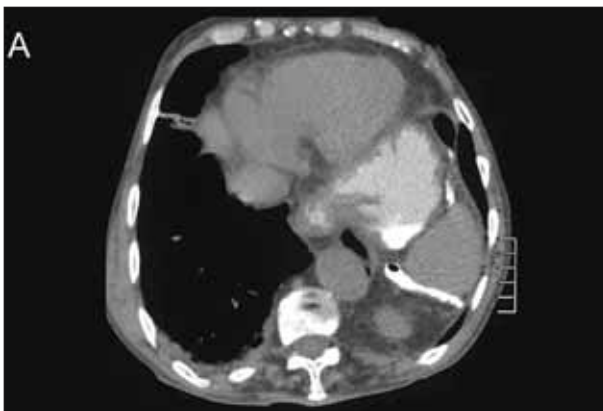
Axial non-contrast CT of thorax (A) and upper abdomen (B) shows bilateral Bochdalek hernia containing fat tissue on the right side, and small intestine, spleen, kidney, and adrenal gland on the left side
